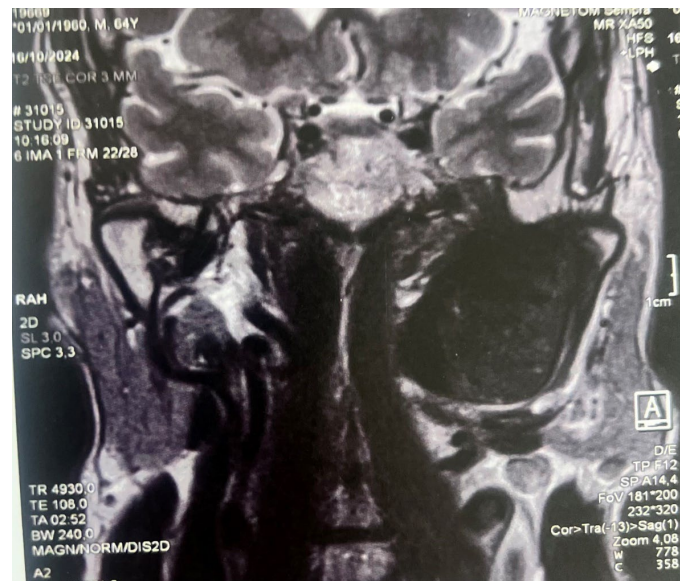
Coronal section of a parotid MRI showing a lesion centered in the left infratemporal fossa with extension into the ipsilateral parapharyngeal space.
